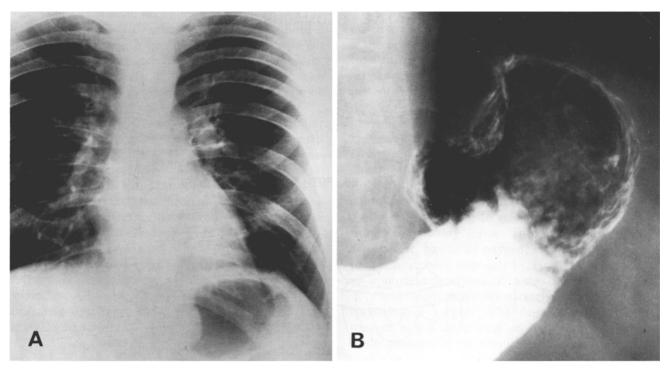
Nissen fundoplication. A The characteristic mass in the area of the gastric cardia is well seen in this PA chest radiograph. B Barium examination reveals a smoothly marginated mass distorting the gastric outline in the area of the exophagogastric junction. Despite the absence of surgical clips the possibility of surgery should always be considered when evaluating a stomach with this appearance. (See acknowledgment on page 255)
